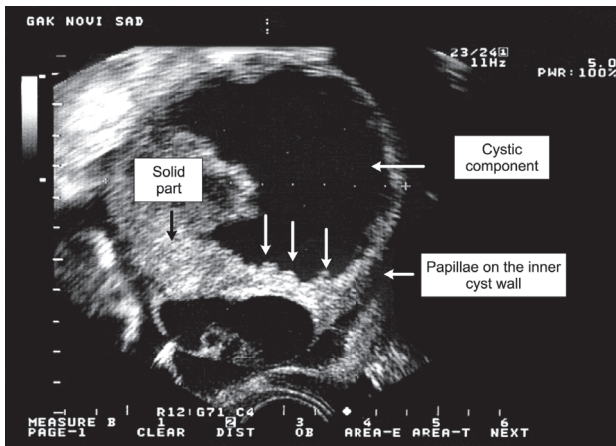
Poorly differentiated papillary serous cystadenocarcinoma, FIGO stage III. Total sonographic score: 8.
